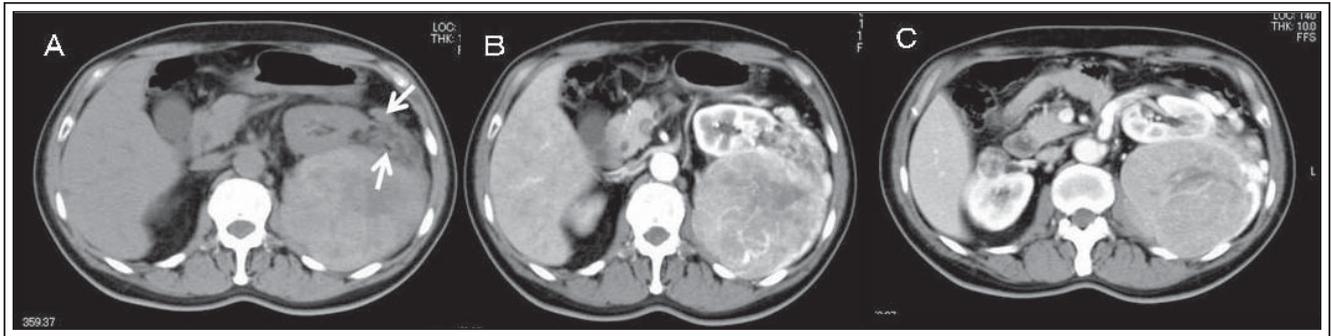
(A) The left side renal tumor was pedunculated. The CT image shows a space-occupying lesion of mixed attenuation interspersed with areas of fat attenuation in a stalk of tumor (arrow). (B) Marked enhancement of the tumor parenchyma is noted, with a non enhancing, patchy internal area. (C) A small tumor with the same appearance is seen in the right kidney.
